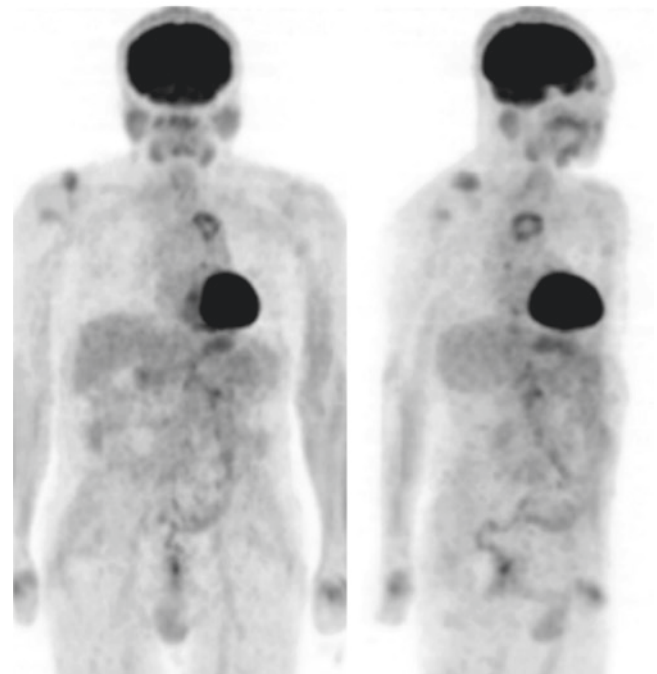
Anterior and lateral MIP images of FDG-PET/CT after antibiotics therapy. FDG uptake by aortic graft was decreased significantly
